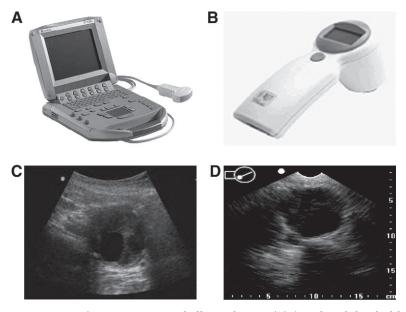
SonoSite Titan (SonoSite Inc., Bothell, Washington) (A) and Mobile Bladderscan BVI 6400 (Diagnostic Ultrasound, Bothell, Washington) (B). (C, D) Images of an AAA obtained by these 2 devices.
